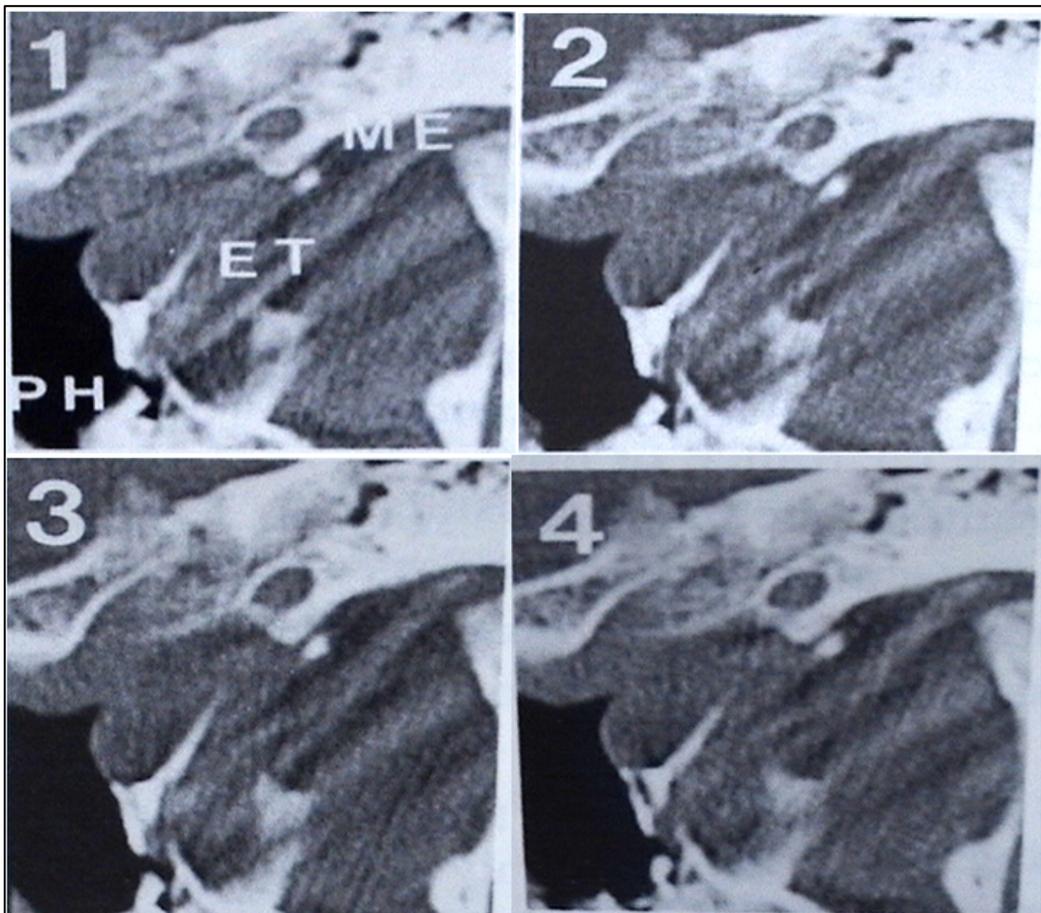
Contrast sequential CT in a perforation case before (1), during (2) and at the end of (3) swallowing
